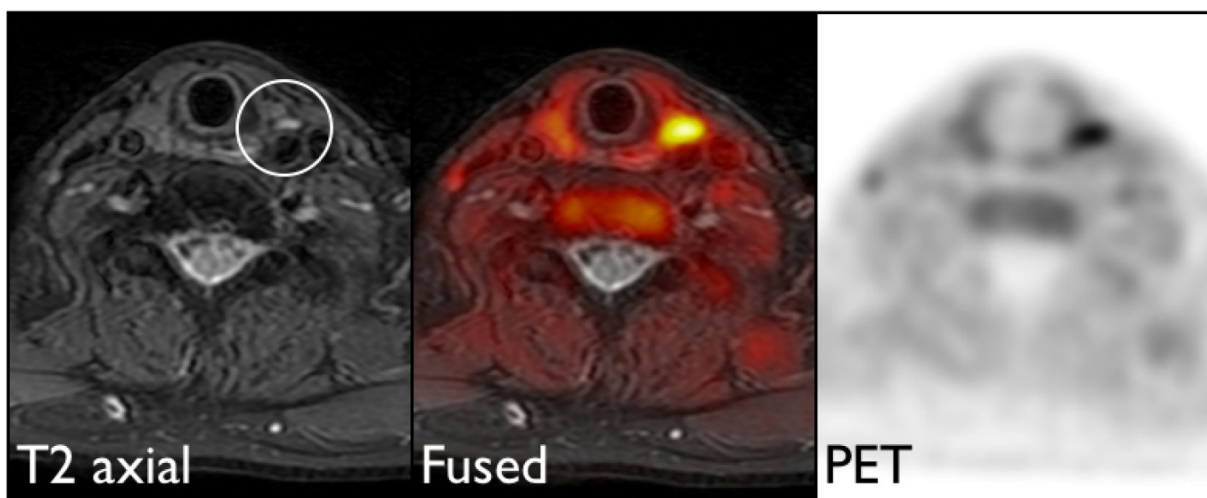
T2 image, FCH PET image, and fused FCH PET/MRI image in a patient with pHPT and negative MIBI. A clear focus of tracer uptake is noted posterior to the left thyroid with associated T2 hyperintense nodule, consistent with a parathyroid adenoma. On surgical exploration this was found to be a parathyroid adenoma.
